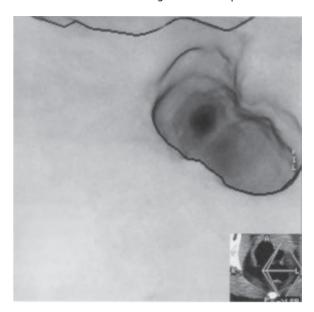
CT colography ('virtual colonoscopy').
